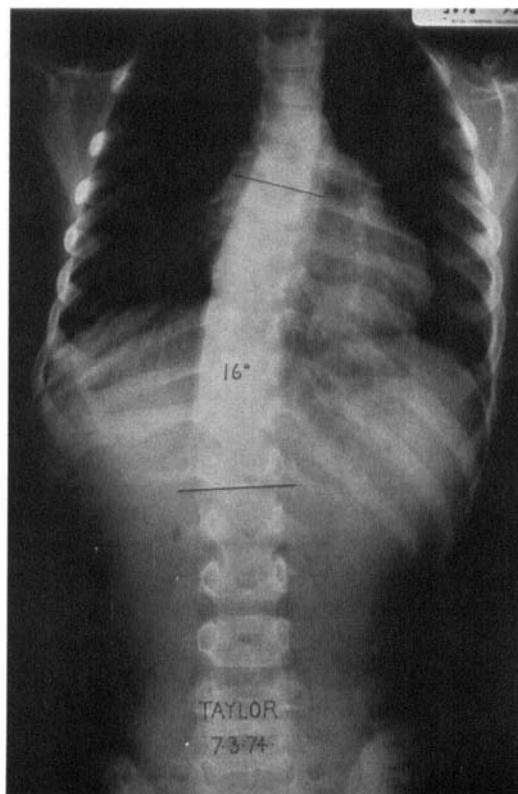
a, The pre-operative radiograph of patient No. 14 with infantile idiopathic scoliosis, a thoracic curve of 45° and a lumbar curve of 15°. b, The same patient 2 years after surgery. The thoracic curve is now 16° with fusion between five ribs. There is also resolution of the lumbar curve, though this did not always occur.
